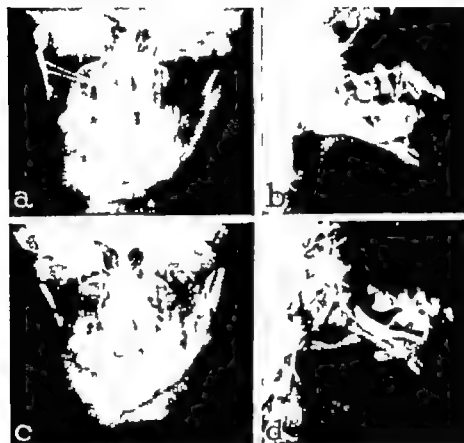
Case 1. x-ray of the procedure. a and b The original loss and occlusion. The wire shadow in a is a hairpin. c and d Rib graft (right) elastic traction and fixation cap splints (left)
